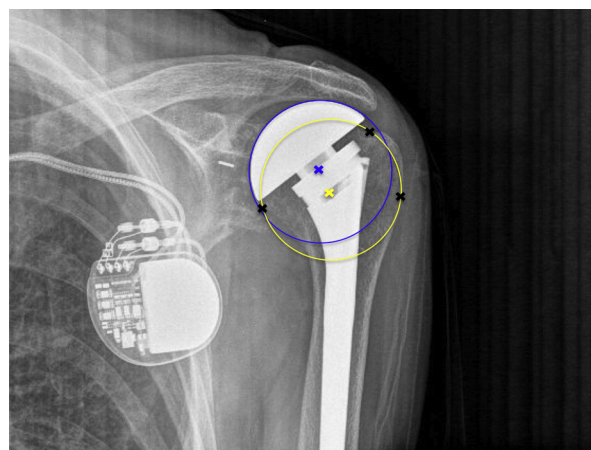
A postoperative AP radiograph of a patient demonstrating the anatomic circle with its COR (yellow circle) and the postoperative implant circle and its COR (blue circle). The three preserved bone landmarks (black x) used to generate the anatomic circle are also depicted.
